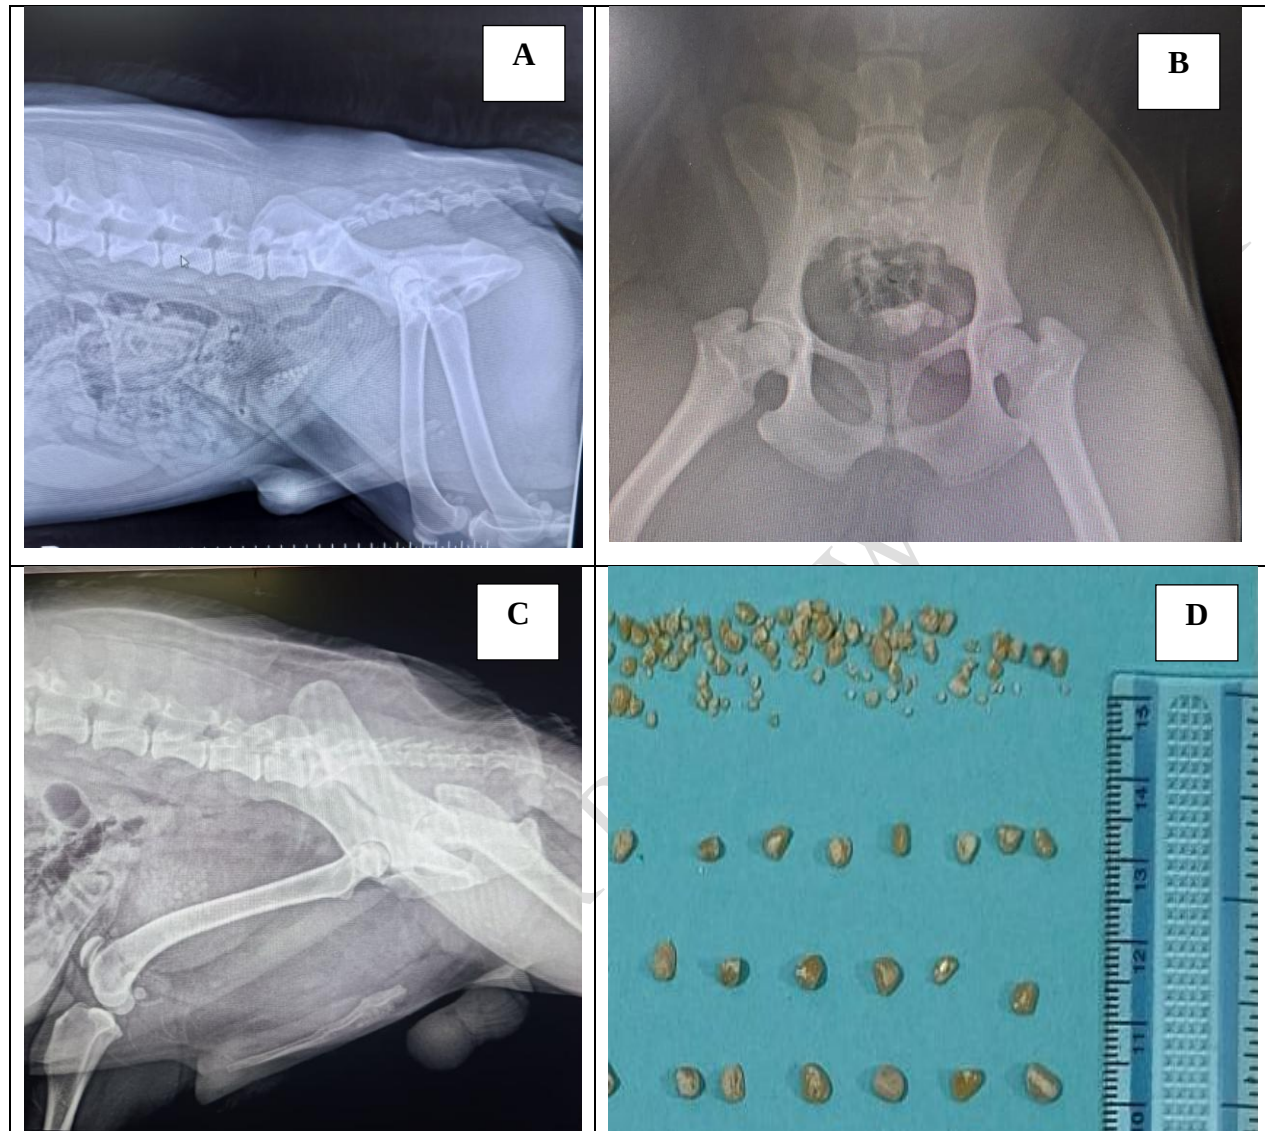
Figures showing preoperative radiographic images of different cases in the present study (A to C) and retrieved urinary stones from the bladder (D)
